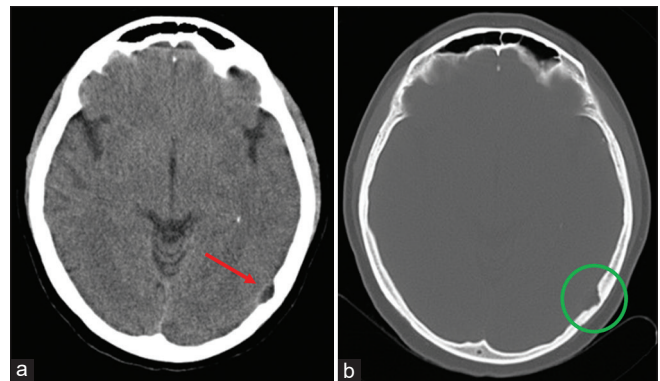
Computed tomography of the head showing in a (small arrow) left extra-axial parietooccipital focal hypoattenuation and in b (green circle) adjacent bone erosion.
